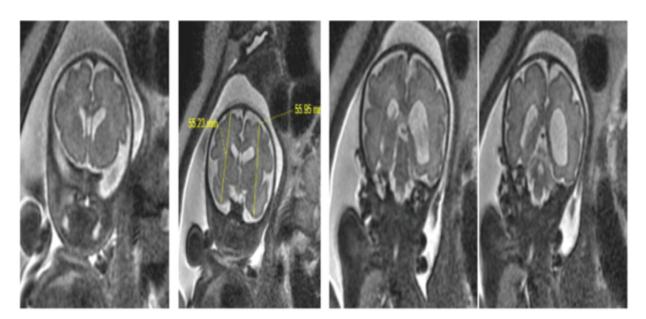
Magnetic resonance imagings of hemimegalencephaly.
